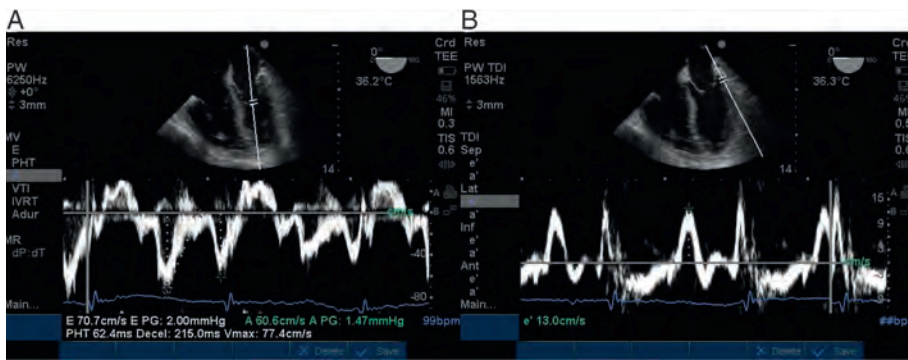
A, Mitral valve inflow. B, TDI of lateral mitral annulus. $E = 70.7 \text{ cm/s}$; $e' = 13.0 \text{ cm/s}$; $E/e' = 5.4$. TDI = tissue Doppler imaging.
